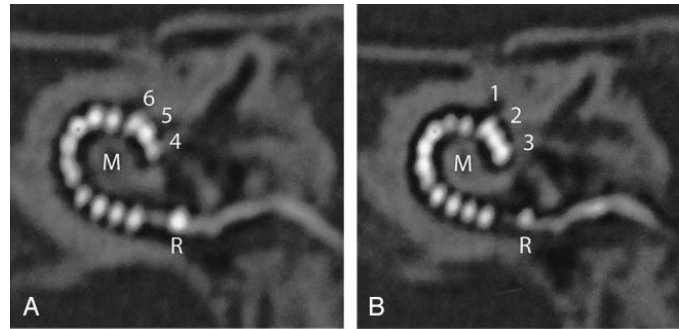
CT scan of an implanted cochlea (from [Verbist 2005])
